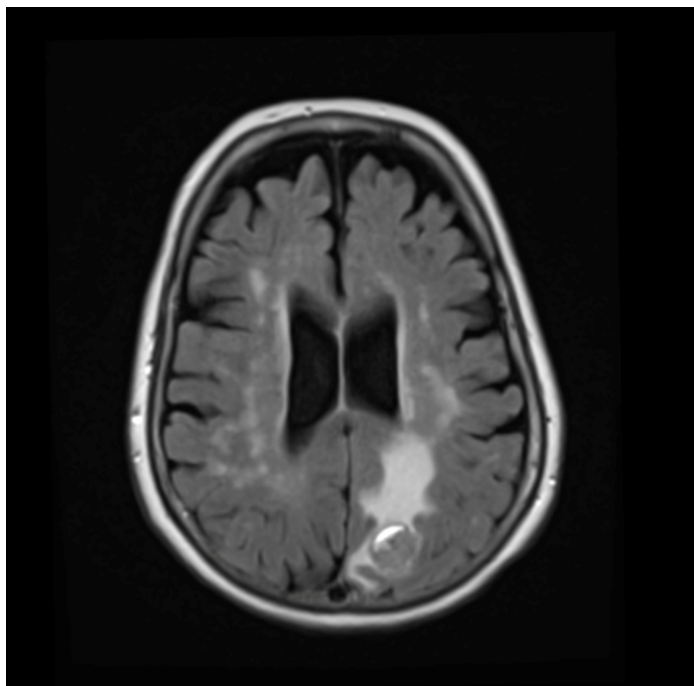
Depiction of FLAIR MRI sequence demonstrating a metastatic lesion in the left occipitoparietal region with surrounding vasogenic edema extending into the centrum semiovale of the left parietal lobe.
